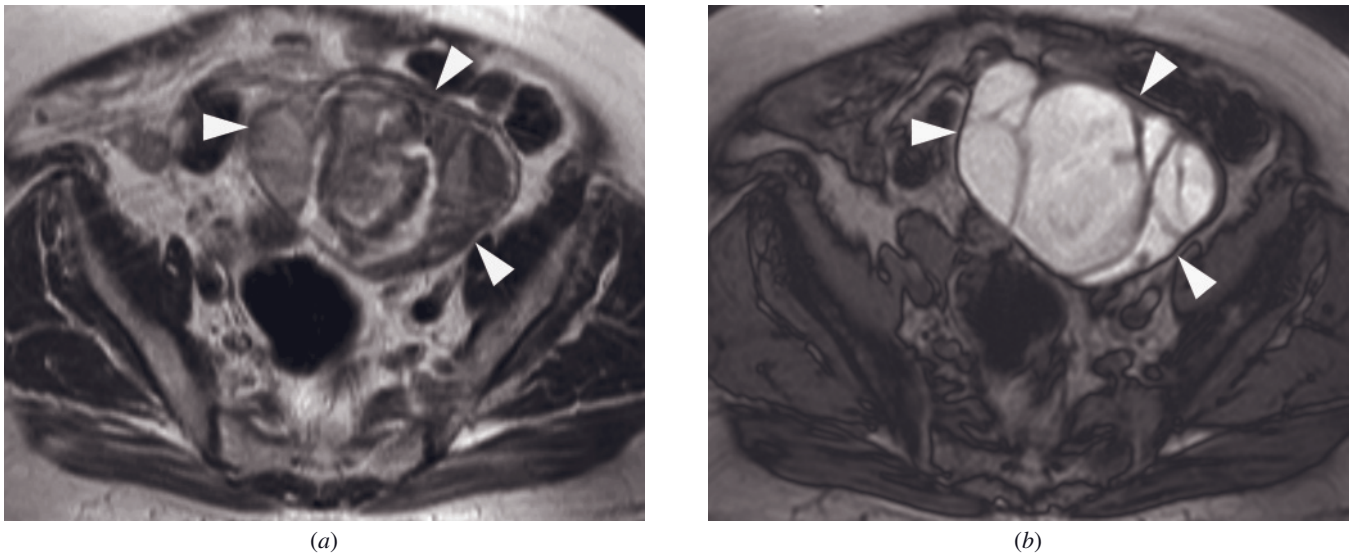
Endometrioid adenofibroma arising in an endometriotic cyst. Transverse T2-weighted ETSE (*a*) and out-of-phase T1-weighted gradient-echo (*b*) images show a septated mass (arrowheads, *a*, *b*) with heterogeneous high and low signal intensity on T2-weighted images (*a*) and slightly heterogeneous high signal intensity on T1-weighted images (*b*), consistent with blood products. Pathologic evaluation of the resected mass revealed benign endometrioid adenofibroma in an endometriotic cyst. (Courtesy of Claude Sirlin, M.D., Department of Radiology, University of California, San Diego).
